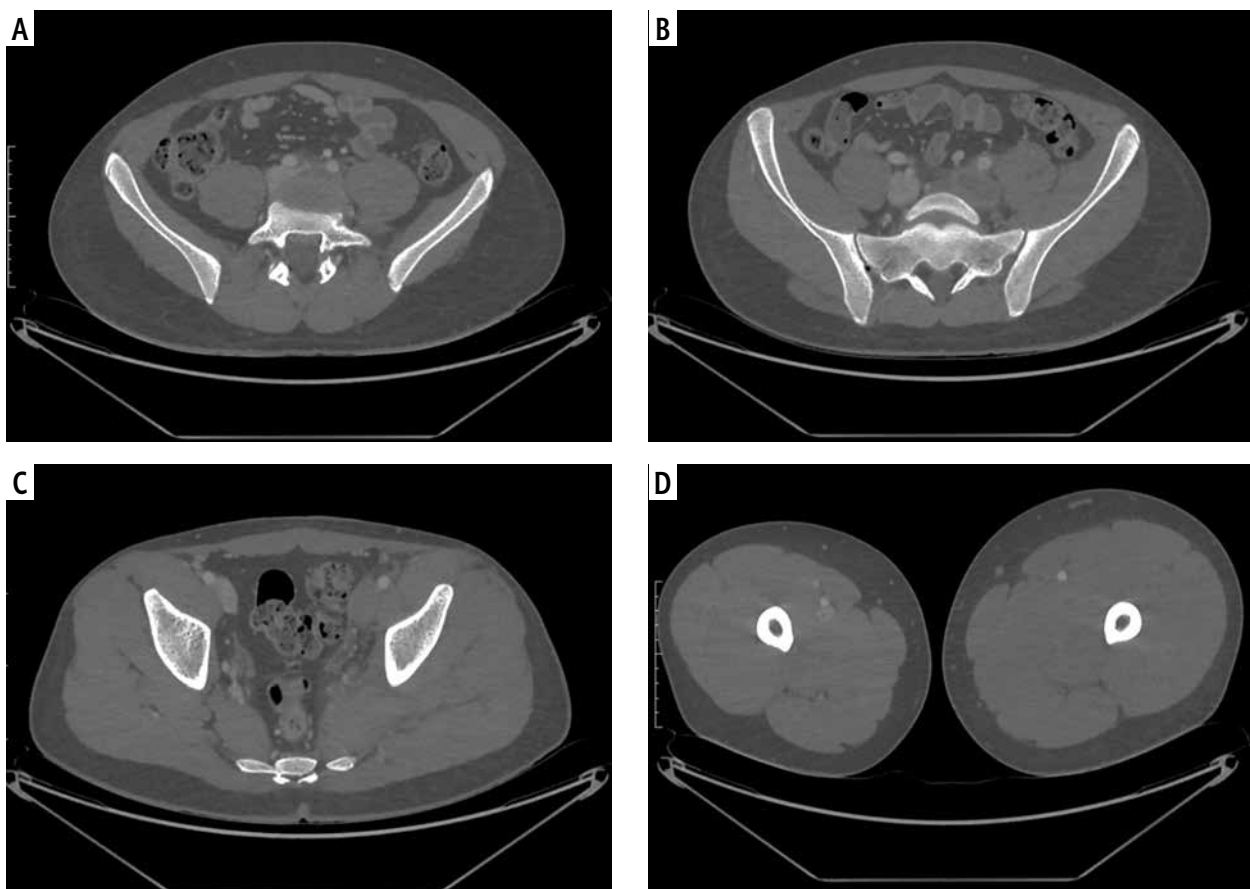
Computed tomography phlebography. A) Image of thrombus positioned in left, B) common iliac vein, C) external iliac vein, and D) femoral vein
